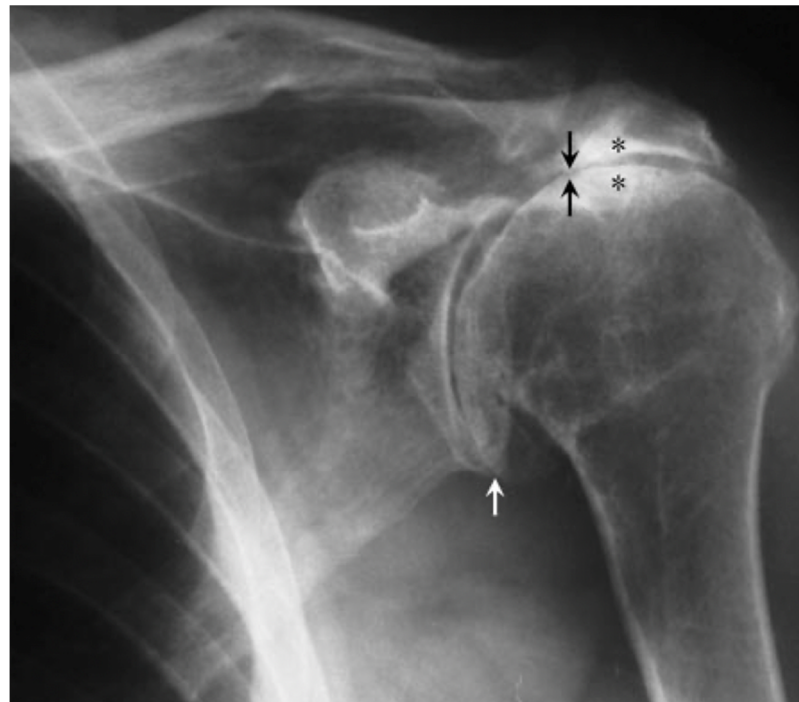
AP X-ray of chronic rotator cuff tear. Black arrows show decreased acromio-humeral distance suggesting upward migration of humerus. * Shows sclerosis, subchondral cysts in greater tuberosity and acromion. White arrow shows osteophytes. (30)
